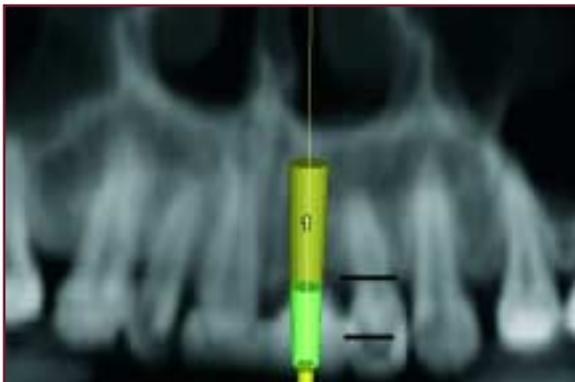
CT with superimposed lines showing less than 5 mm from contact point to osseous crest to create papillae formation.
